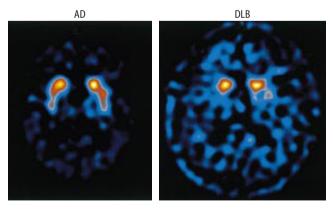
FP-CIT SPECT in patients with Alzheimer's disease (AD) and Dementia with Lewy bodies (DLB). Tracer uptake is considerably reduced in DLB [39]
